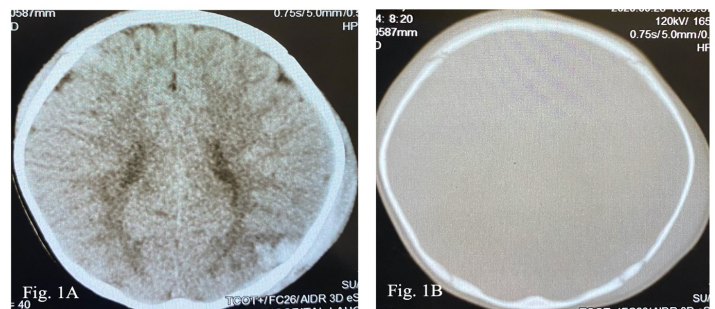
Computerized tomography (CT), axial section showing a contusion over the left parietal area and subgaleal hematoma. B) Axial section at the same level showing a linear fracture of the parietal bone.
